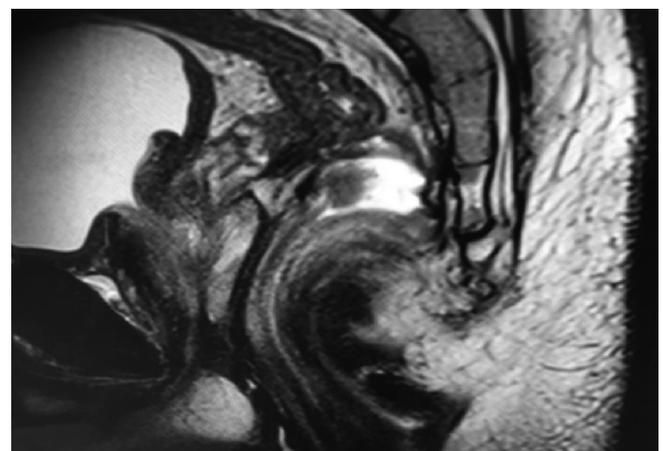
MRI picture of the rectal adenoma.
